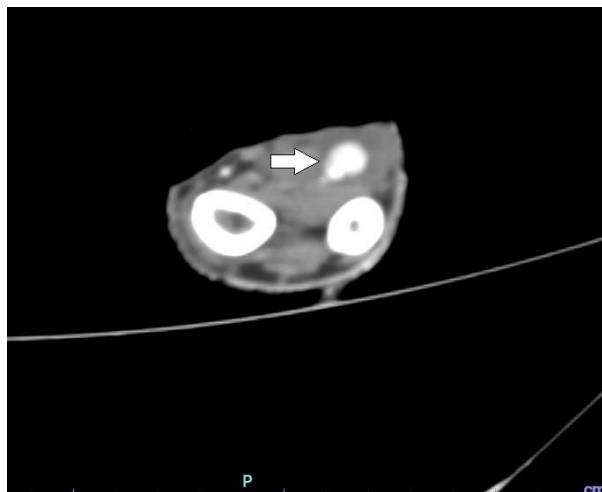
Computed tomography angiography Showing the presence of a pseudoaneurysm arising from the distal ulnar artery
